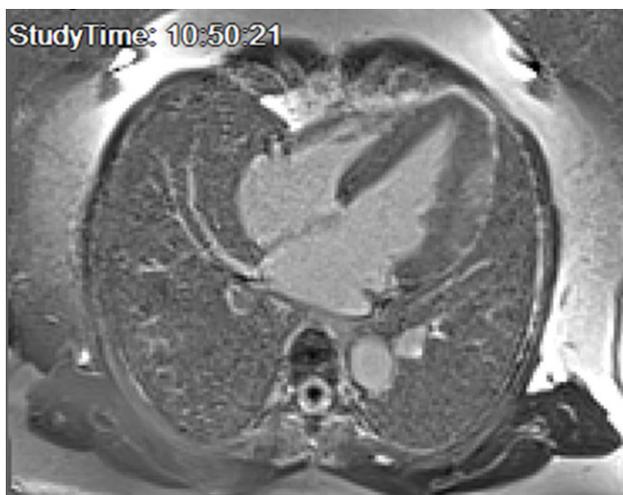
4-6 Cardiac MRI
